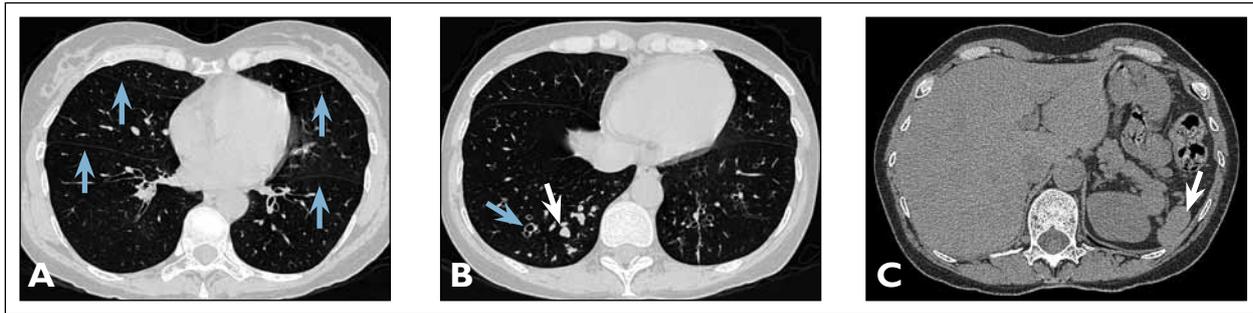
Lung image from thin section computed tomography (CT) study showing bilateral oblique and 'horizontal' fissures (marked with blue arrows). FIGURE 1B Lower zone lung CT section showing basal bronchiectasis (example marked with blue arrow) and nearby dilated bronchi plugged with mucus (example marked with white arrow). FIGURE 1C Upper abdominal CT section showing small splenunculus (marked with white arrow).
